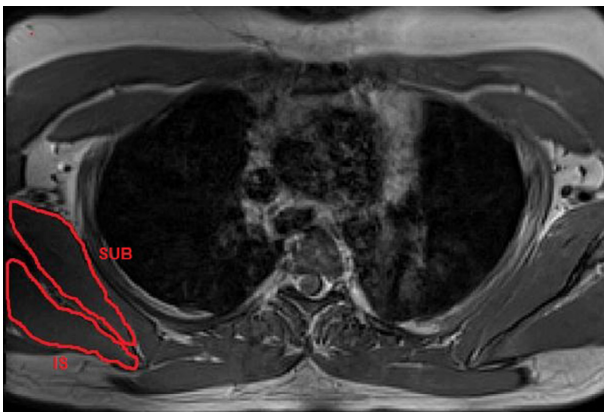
Region of interest (red outline) for the subscapularis (SUB) and infraspinatus (IS) muscles in the T2-weighted (T2 map) image at the level parallel to T3-T4.
